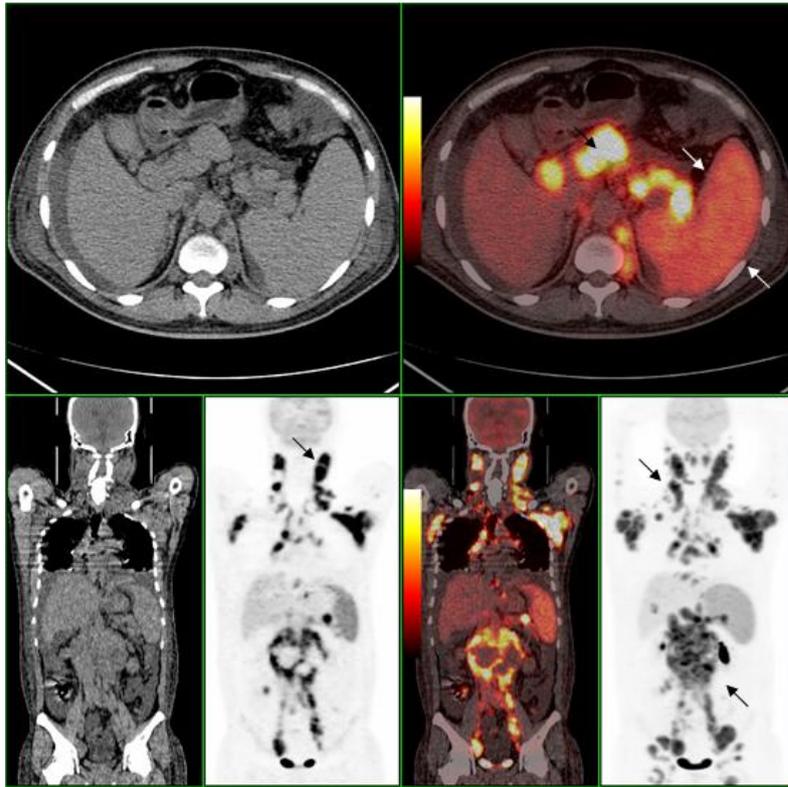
Stage IIIS NHL with splenic involvement in a 35-y-old man with HBV. The axial and coronal ^{18}F -FDG PET/CT image shows diffusely increased splenic uptake of ^{18}F -FDG, which is higher than hepatic uptake and moderate ascites. The splenic index was 807 mL, with S/L ratio of 1.9. Coronal PET/CT and projection images show multiple high metabolism lymph nodes and diffuse splenic hyper-metabolism. The patient had HBV infection with liver function damage, but there is no evident of NHL liver involvement.
